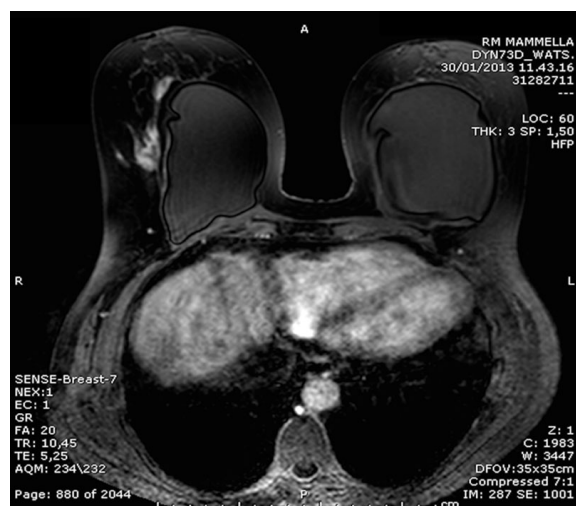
Magnetic resonance imaging of the breast: demonstrating a conglomerate coalescent mass in the superior right breast upon the implant
